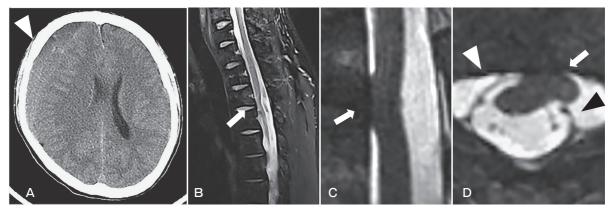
Preoperative head CT and spinal MR images. A, A head CT image showed the right chronic subdural hematoma (arrowhead) with midline shift; B, A sagittal T2-weighted image revealed the ventral deviation of the spinal cord at the Th3/4 level (arrow); C, on a sagittal CISS image, the spinal cord was located ventrally (arrow) and no CSF was seen ventral to the cord.; D, On an axial CISS image, the spinal cord was herniated (arrow) through the inner layer of the dura mater (black arrowhead) and attached to the outer layer (white arrowhead).
